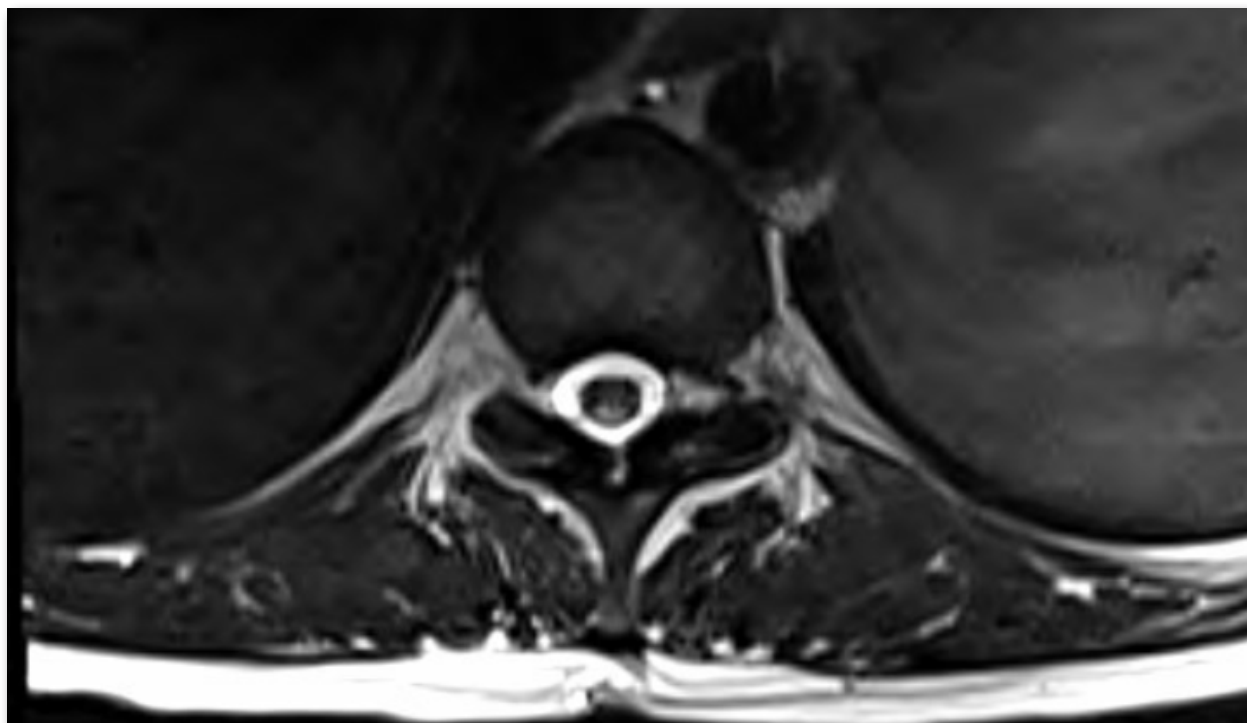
MRI of thoracic spine at T9 level showing increased attenuation of the dorsal spinal cord (arrow). Read showed abnormal patchy hyperintensity in the dorsal aspect of the spinal cord extending from the cervicothoracic junction to the distal spinal cord just above the conus medullaris at L1, with patchy linear gadolinium enhancement involving the dorsal spinal cord at the mid-thoracic levels, particularly from approximately T5 through T7-T8.
